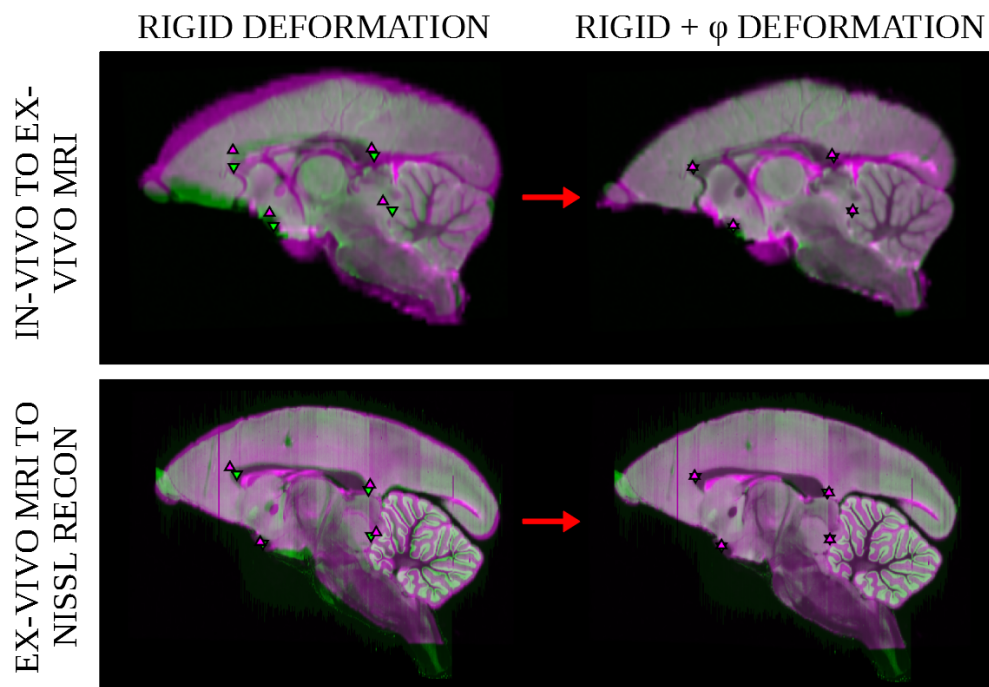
Image overlap after volume to volume registration. Registration accuracy was measured to validate quantitative distortion measurements. The top row shows overlap of a subject’s in-vivo MRI (magenta) mapped to the ex-vivo MRI (green) and the bottom row shows overlap of a subject’s ex-vivo MRI (magenta) mapped to the nissl reconstruction (green). Landmarks located near the mid-sagittal plane from the landmark transfer analysis are overlaid on each image: posterior and anterior corpus callosum, anterior commissure, and the fastidium of the fourth ventricle.
